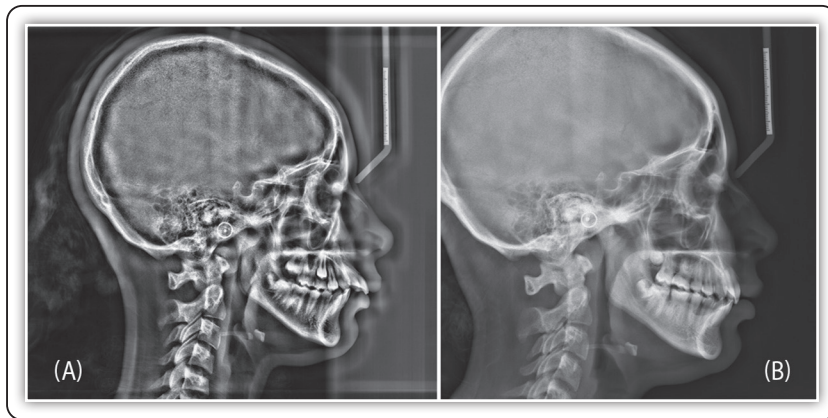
(A): Pre-operative lateral cephalometric radiograph, (B): Post-operative lateral cephalometric radiograph
